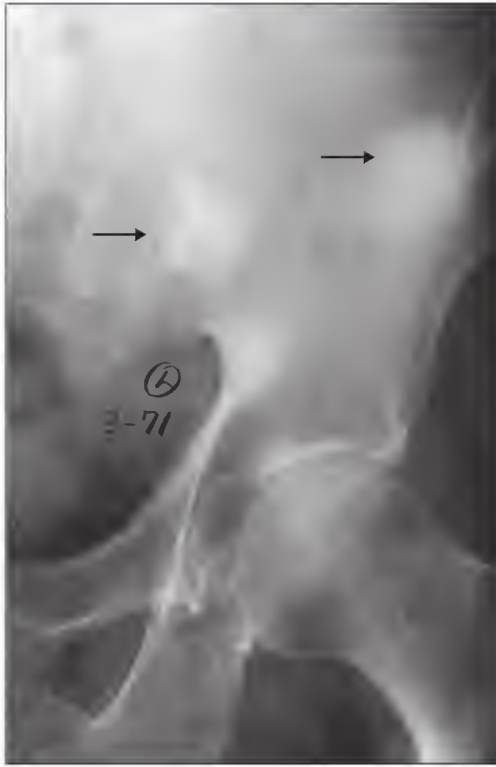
Radiograph of a pelvis showing poorly defined radiodense lesions (arrows). These lesions are osteoblastic metastases from metastatic breast carcinoma.
